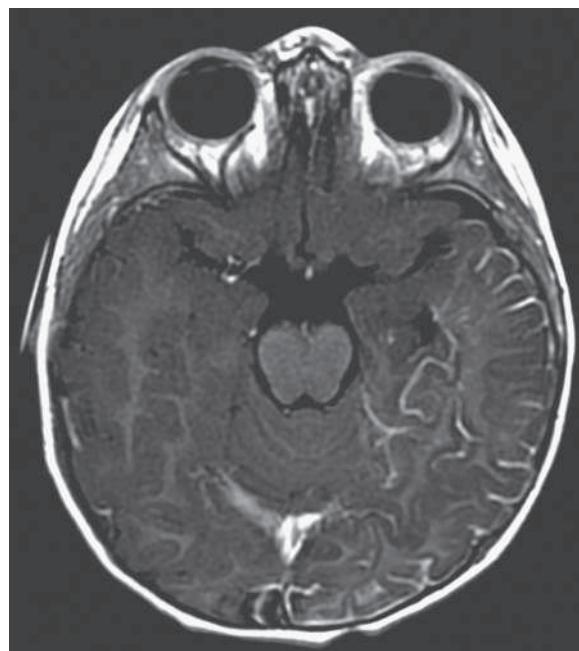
Gadolinium-enhanced axial T1 fluid-attenuated inversion recovery (FLAIR) images of a 15-mo-old with Sturge-Weber syndrome show leptomeningeal enhancement in the left hemisphere.
